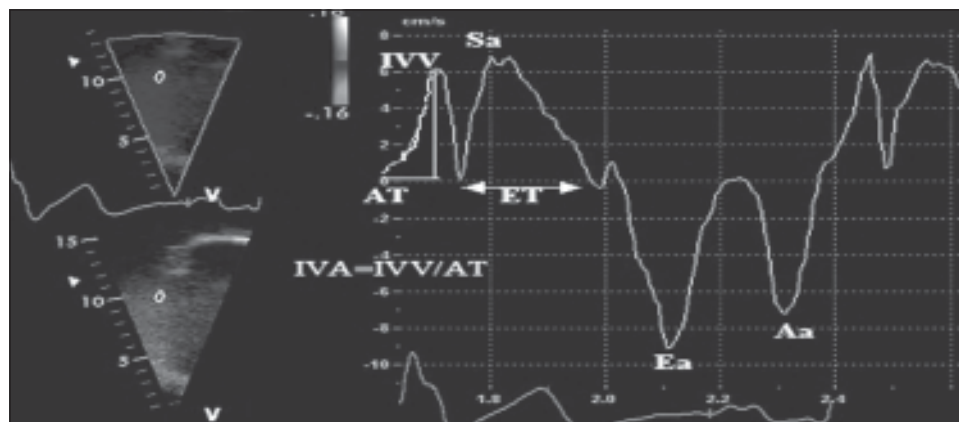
Doppler tissue velocities and time intervals obtained at lateral tricuspid valve annulus. Aa, Peak velocity during atrial contraction; AT, acceleration time; Ea, peak velocity during early diastole; ET, ejection time; IVA, myocardial acceleration during isovolumic contraction; IVV, peak myocardial velocity during isovolumic contraction; Sa, peak velocity during ejection period of systole.
